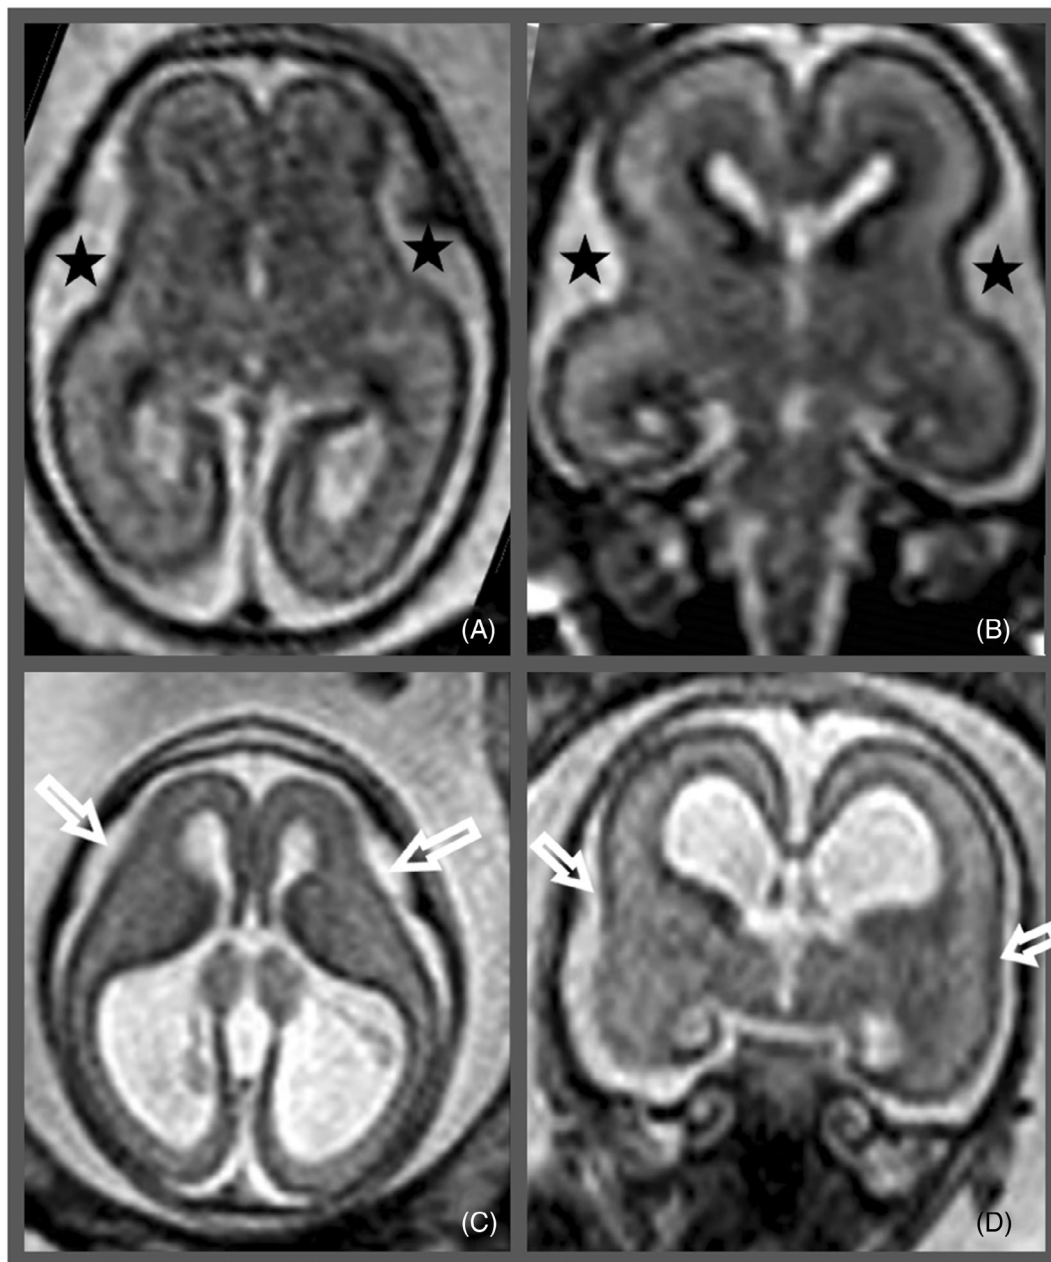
Lissencephaly, 21 GW: (A) axial and (B) coronal T2-weighted images in a normal individual shows physiologic appearance of the Sylvian fissures at this age (stars). (C) axial and (D) coronal T2-weighted images in a patient with ventriculomegaly shows absence of primary sulcation with flattening of the fronto-temporal regions (arrows)
